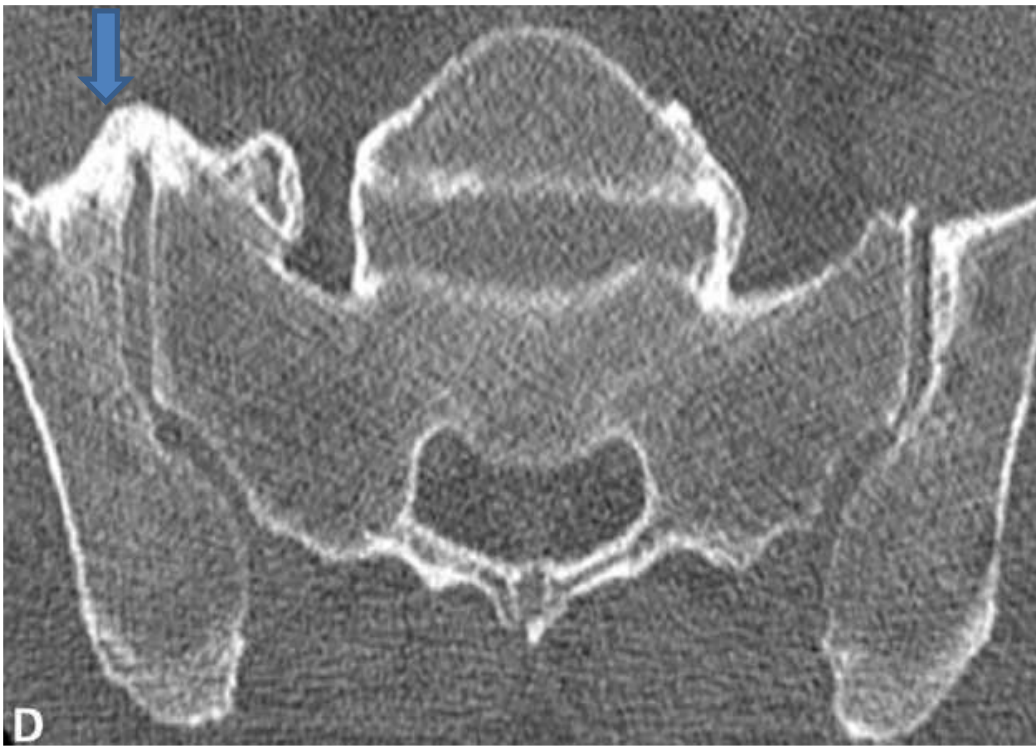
84-year-old man with diffuse idiopathic skeletal hyperostosis. Axial CT image of sacroiliac joints (SIJs) shows right-sided intraarticular SIJ ankylosis (arrowheads) as well as anterior bridging. Left SIJ is intact.
